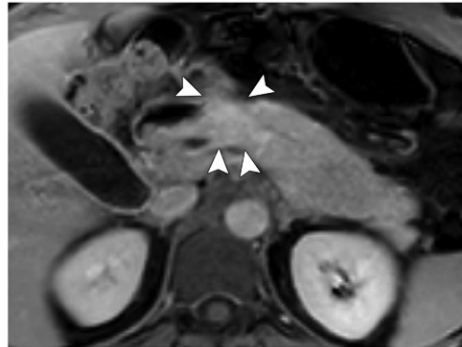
Type 2 AIP in a 42-year-old man. (a) Axial T2-weighted MR image through the proximal pancreas shows an ill-defined intermediate-signal-intensity masslike lesion (arrows). (b) Coronal T2-weighted MR image through the pancreatic head shows the narrowed caliber of the pancreatic duct traversing through the same region (arrow). Note co-existing focal stricture involving the distal common bile duct (arrowhead). (c) Axial contrast-enhanced delayed-phase MR image through the same region shows focal masslike lesion (arrowheads). The rest of the pancreas is unremarkable.
